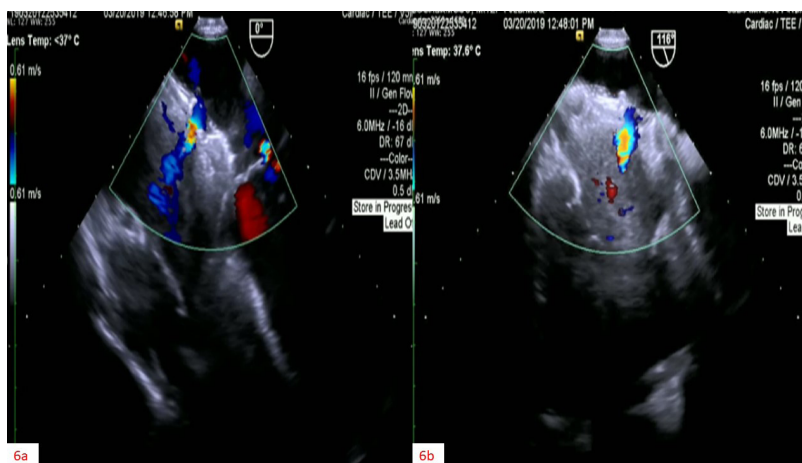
Transesophageal echocardiogram (TTE) pre-device closure, a. 4 chamber view and b. Bicaval view showing the fenestrated ASD device in place with left to right shunt
